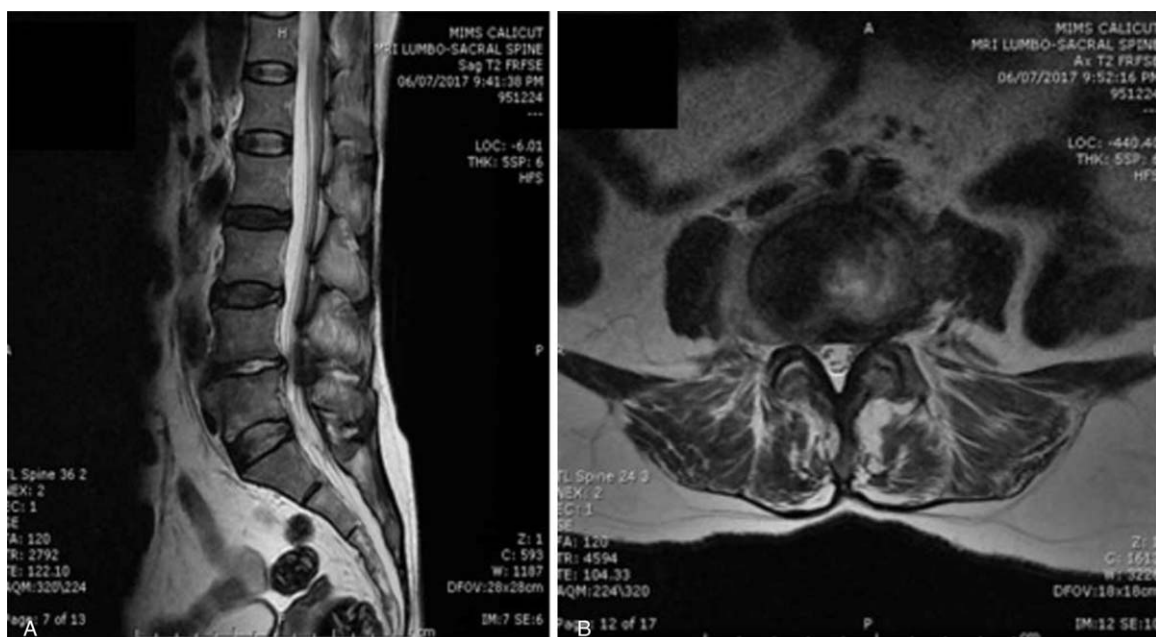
MRI LS spine with contrast showing degenerative changes and diffuse disc bulge at L4-L5 level with lateral recess and neural foraminal narrowing. Reduced L4-L5 disc space with edematous change-likely infective pathology.
